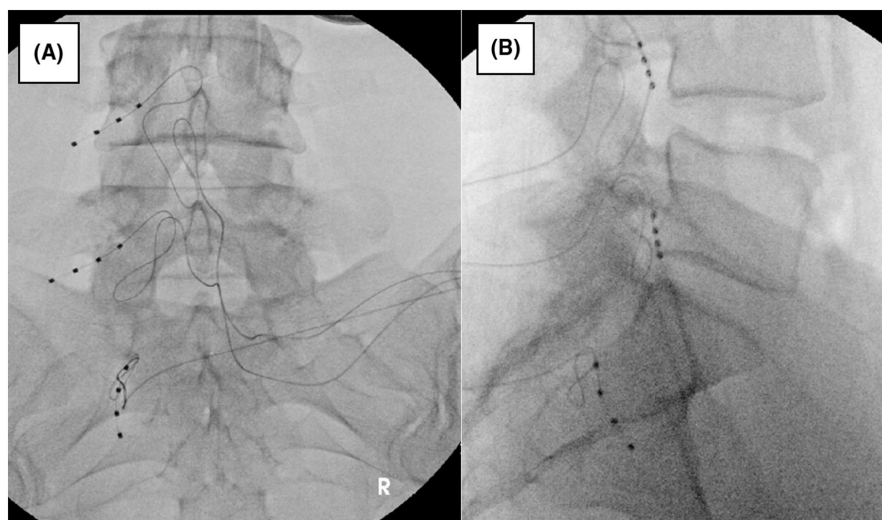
A/P view (A) and lateral view (B) lumbar spine x-ray showing DRG lead placements at L4, L5, S1.
